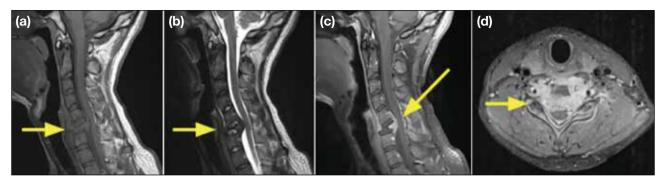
Case 2. Initial magnetic resonance imaging. (a) T1-weighted and (b) T2-weighted sagittal images show vertebra plana of the C6 vertebra with hypointense signals (arrows). (c) Post-gadolinium sagittal image and (d) axial image show avid enhancement of the lesion involving bilateral pedicles with associated extraosseous soft tissue component in the epidural space with severe canal stenosis (arrows).
